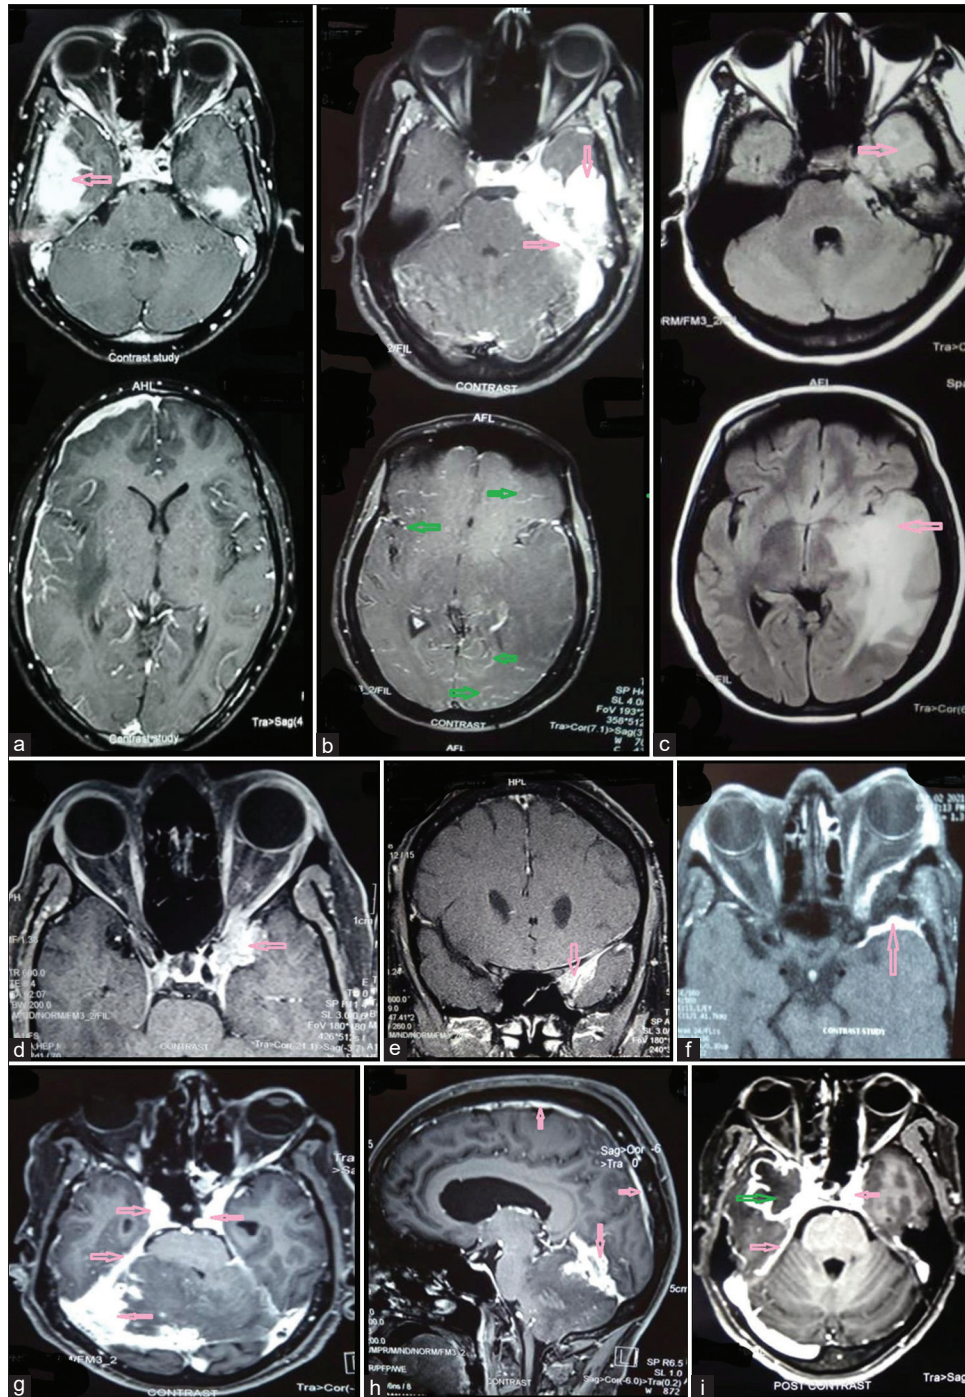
Focal irregular HP. (a) T1 contrast image: patient with AML with nodular pachymeningitis of bilateral temporal lobes (right > left) and patchy involvements of right frontoparietal regions (marked with pink arrows). (b) T1 contrast image and (c) T2 FLAIR image: Patient with TB HP with nodular pachymeningitis involving the left temporal region and the tentorium cerebelli (marked with pink arrows), along with subtle leptomeningeal enhancements (marked with green arrows). Edema is seen in the adjacent brain parenchyma with mass effect (marked with pink arrows). (d) T1 contrast axial image and (e) T1 contrast coronal image: patient with IgG4-RD having focal nodular enhancements involving left cavernous sinus, orbital apex, and medial temporal region (marked with pink arrows). (f) T1 contrast image: patient with idiopathic HP with nodular pachymeningitis involving the left temporal region (marked with pink arrow). (g) T1 contrast axial image and (h) T1 contrast sagittal image: patient with TB HP with nodular enhancements of left tentorium, bilateral medial temporal and cavernous sinus regions, along with falx cerebri (marked with pink arrows). (i) T1 contrast image: patient with TB HP having nodular enhancements of bilateral medial temporal and cavernous sinus regions and bilateral tentorium cerebelli (marked with pink arrows). There is a TB abscess in the right temporal lobe (marked with green arrow)
